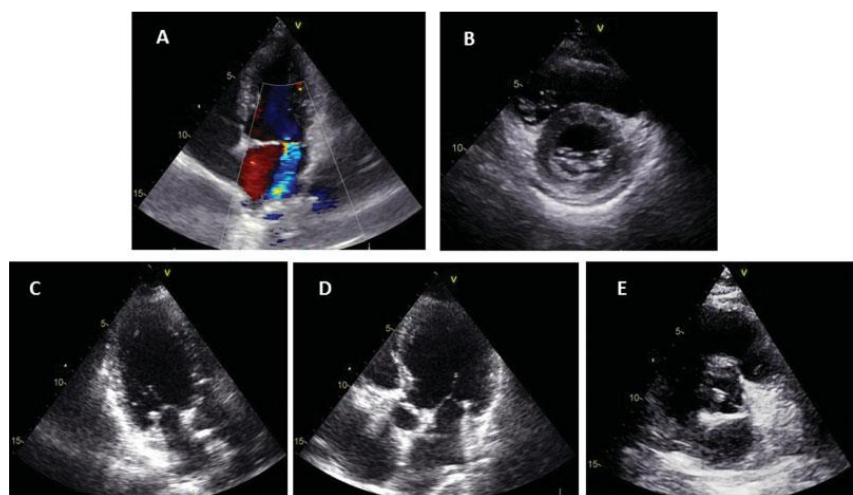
TTE of different APS patients with valvular heart disease. (A) Moderate mitral regurgitation. (B) Mitral valve thickening associated to mild pericardial effusion. (C and D) Calcifications on the posterior mitral leaflet and aortic cusps are presented. (E) Calcifications of aortic leaflets. APS, antiphospholipid syndrome; TTE, transthoracic echocardiography.
